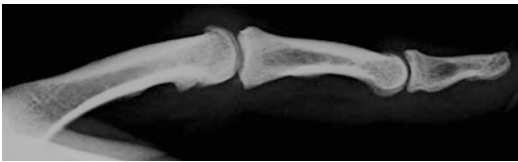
Lateral X-ray of a long-time climber with dorsal and palmar osteophytes
